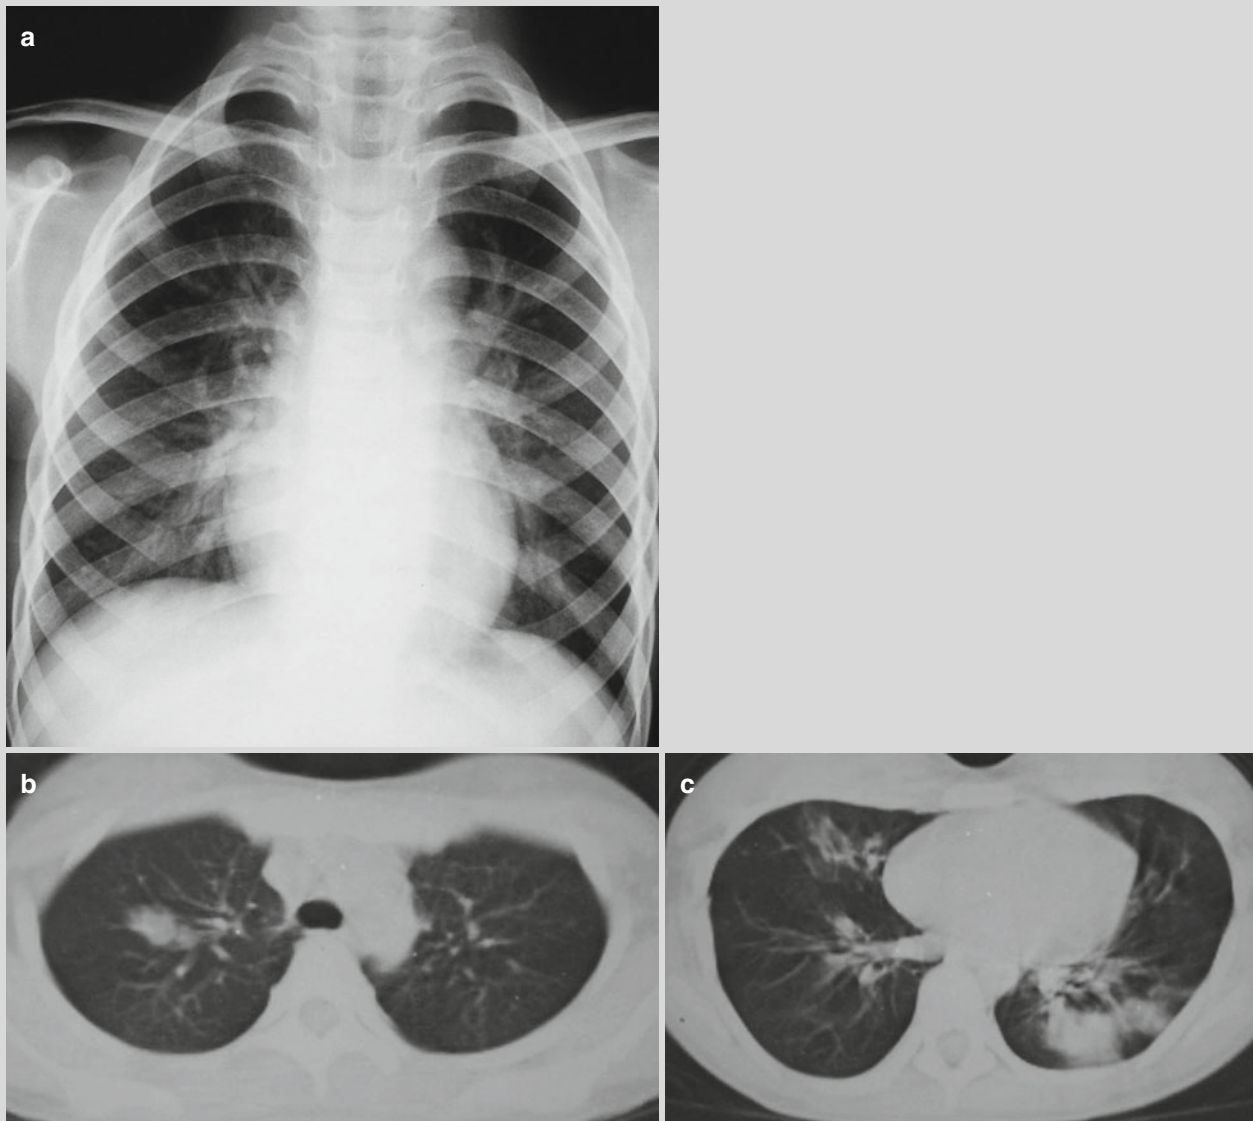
Chest X-ray showed increased lung markings and multiple flakes of poorly defined opacity in both lungs (a); CT scan demonstrated multiple poorly defined consolidation opacity in the right upper lung lobe and the left lower lung lobe; and multiple cords like
